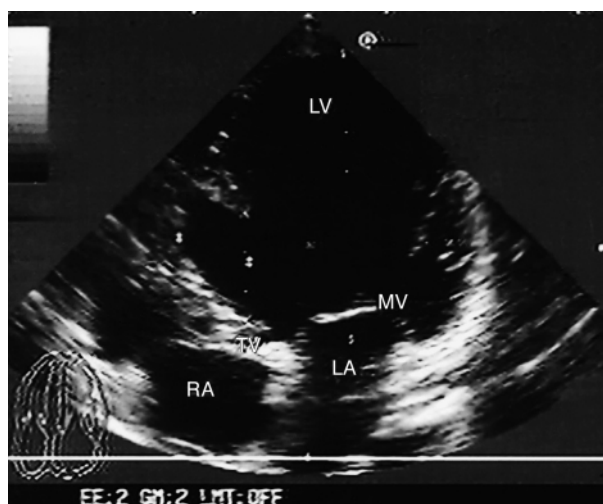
Postoperative echocardiogram. LA = left atrium, LV = left ventricle, MV = mitral value, RA = right atrium, TV = tricuspid valve.
